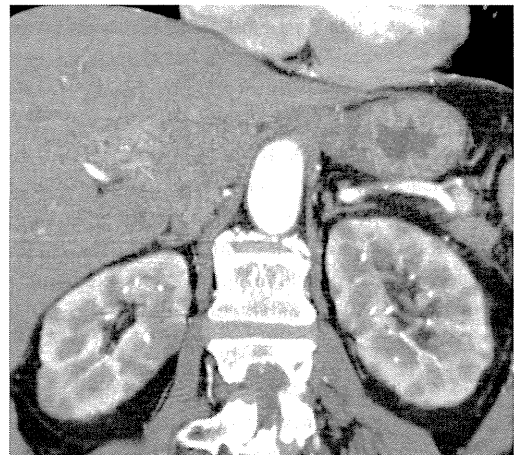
Kidney disease. Dynamic contrast-enhanced CT (arterial phase) shows poorly-enhanced multiple nodules, wedge-shaped lesions, and round lesions in both renal cortices
